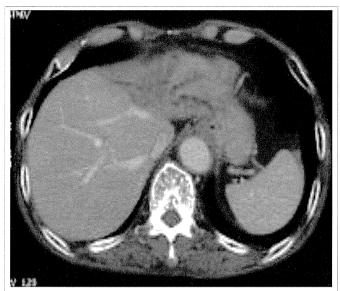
Computed tomography revealed the dilated left intrahepatic bile duct
